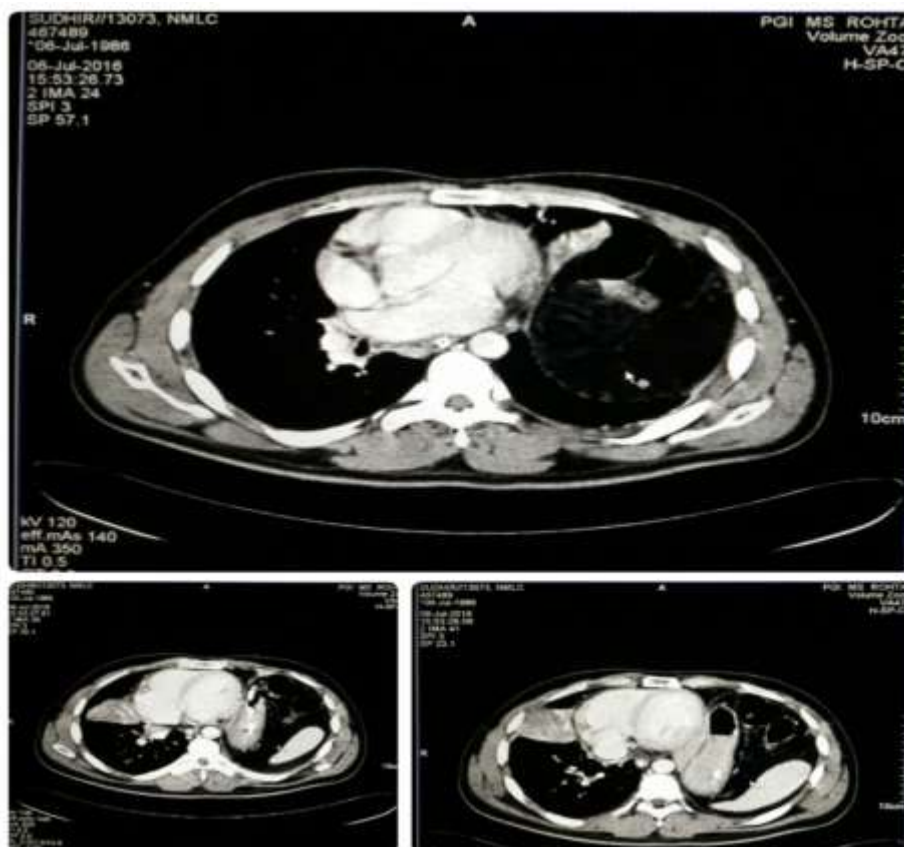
CT chest showing the eventration of the diaphragm on the left side.
